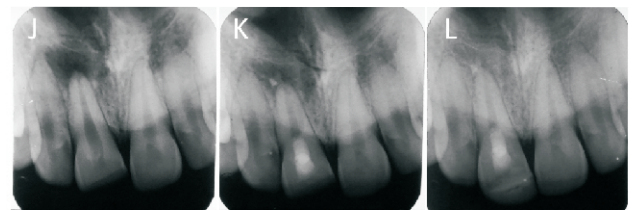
(J) Pre-treatment radiograph of the maxillary right central incisor showing a large periapical radiolucency at the apex. (K) Periapical radiographs obtained at the 6 months follow-up, shows evidence of healing after REPs. (L) Periapical radiograph obtained after 18 months, the periapical radiolucent lesion was completely healed. Tooth was asymptomatic and responded to pulp sensibility tests.
